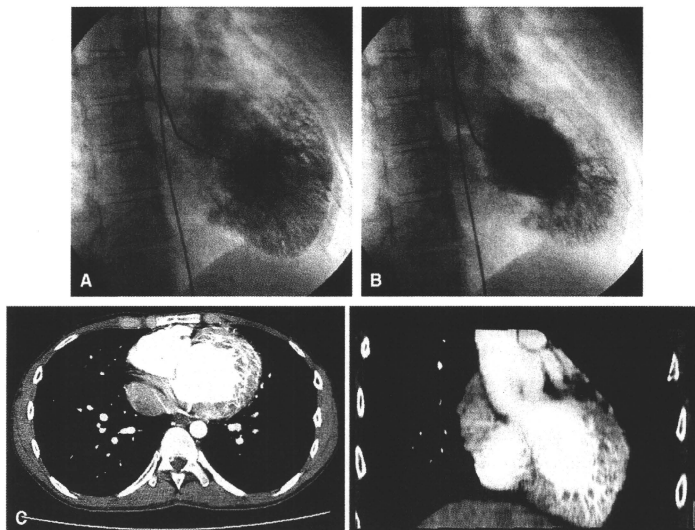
Prominent thick trabeculations and deep intertrabecular recesses in the whole left ventricular wall are shown by LV angiogram at diastolic (A) and systolic (B) phases (CTR = 53%). C, Spongiform myocardium depicted by computed tomography.
